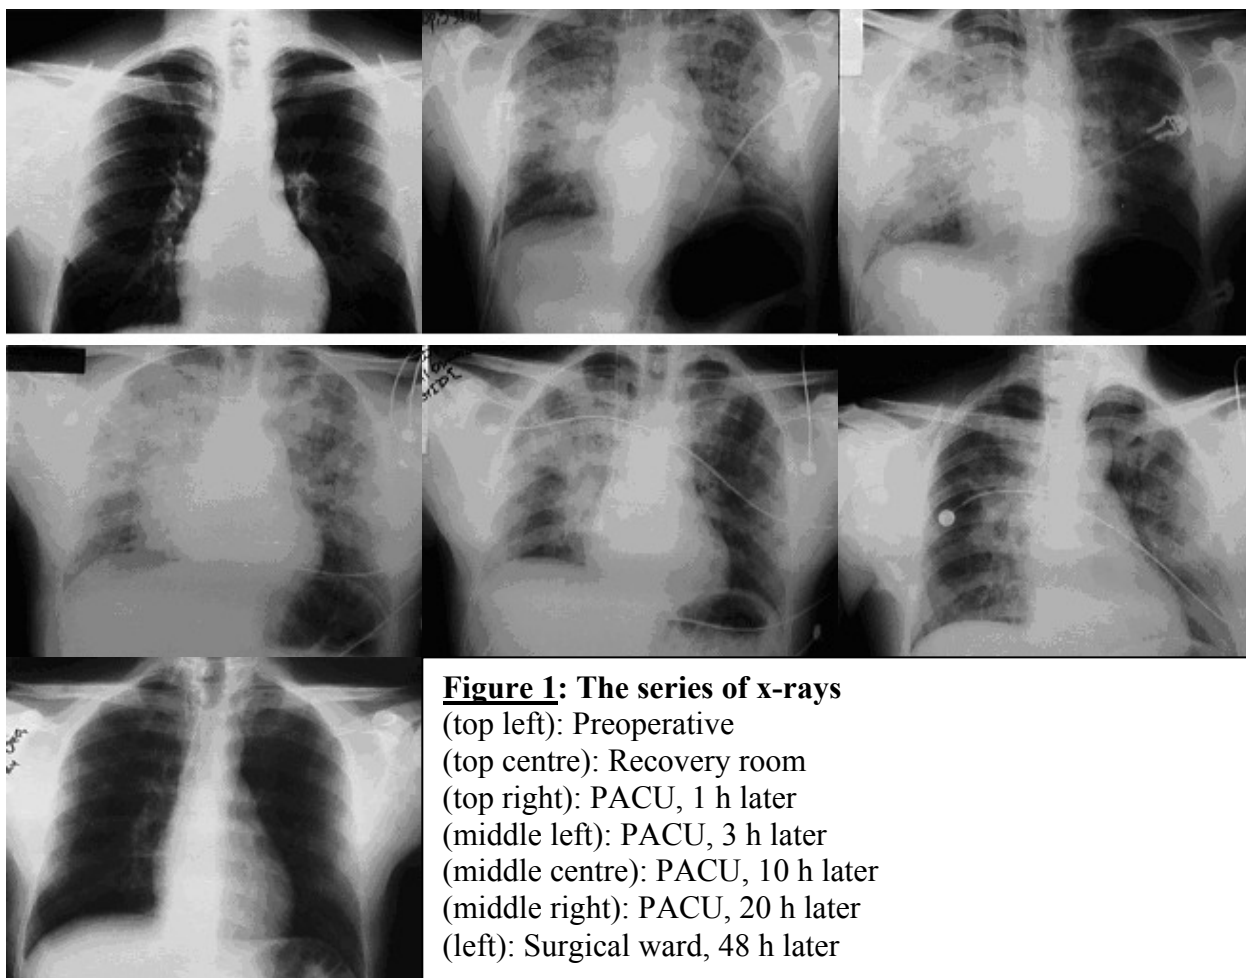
The series of x-rays
